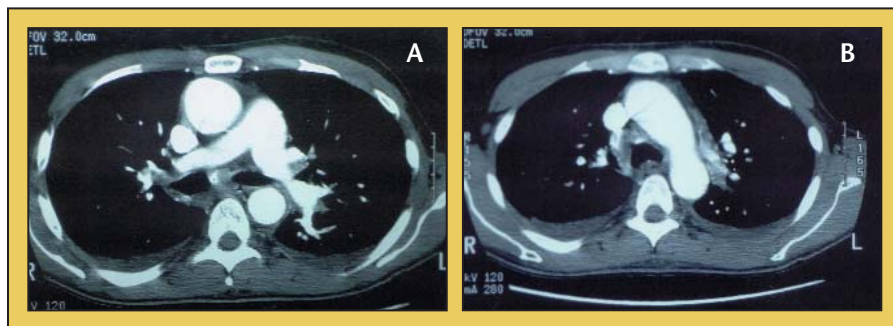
CT scan of chest revealing an ascending aortic aneurysm (A) originating above the aortic valve and (B) involving the aortic arch.
